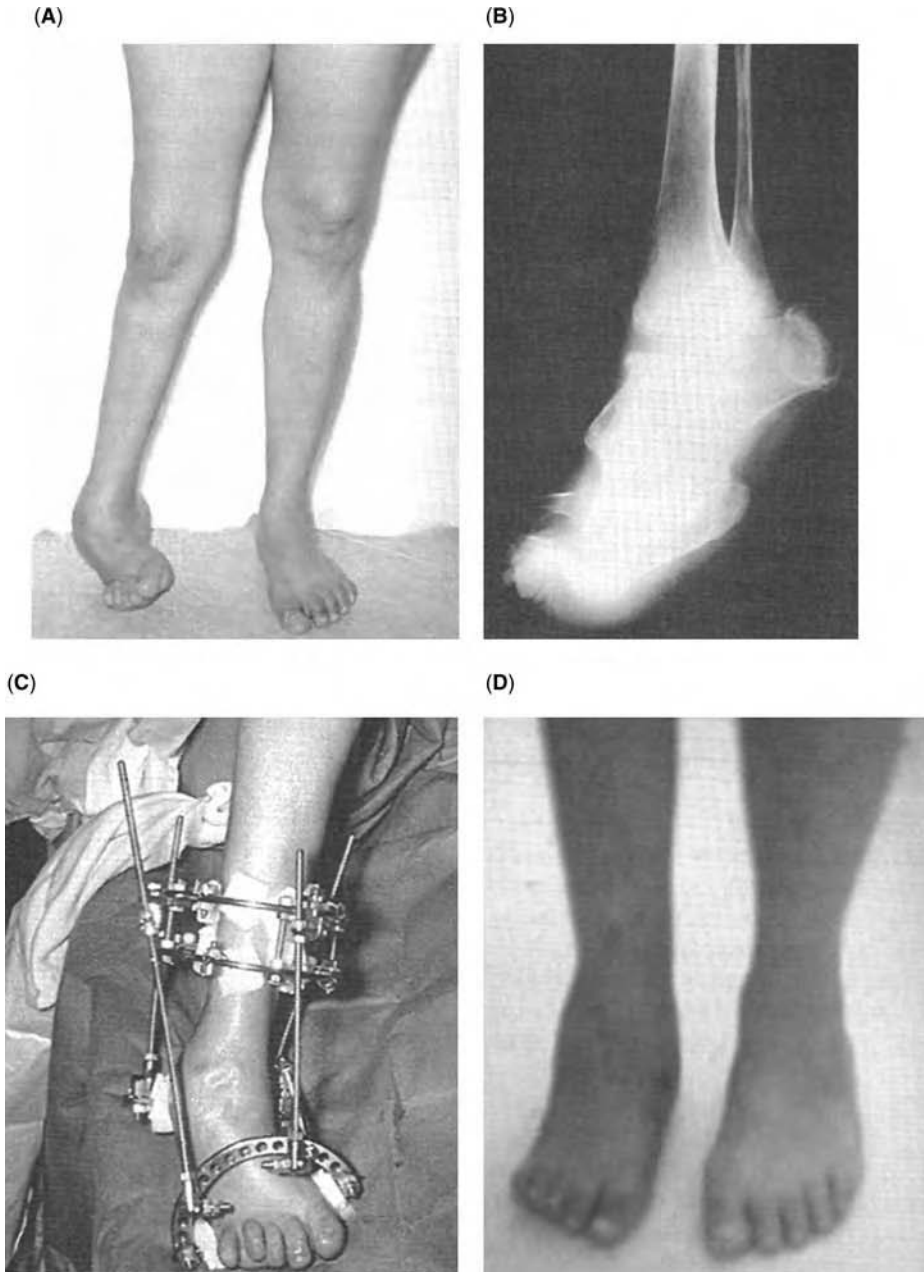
(A) Severe equinovarus deformity in a 42-year-old woman with a history of poliomyelitis since age 14. (B) Radiograph of affected deformity with severe degenerative changes. (C) Application of equinus frame with cavus modification and anterior threaded rods designed to derotate the forefoot. (D) After frame removal, the patient maintained a plantigrade foot and normal shoe wear.
